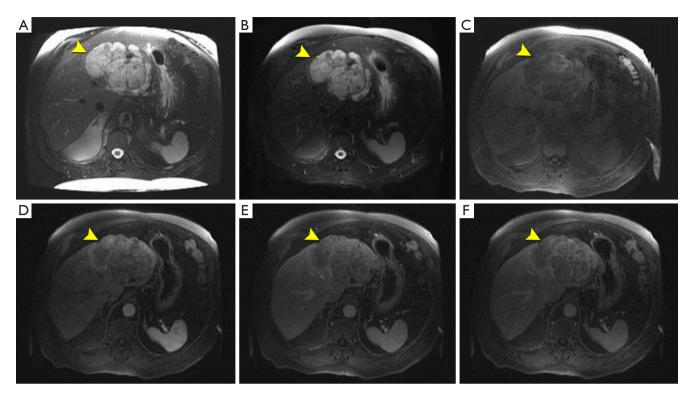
Representative images from the MRI study in Case 1. Axial T2-weighted without fat saturation (A), axial T2-weighted with fat saturation (B), pre-contrast T1-weighted (C) and post-contrast arterial, venous and delayed phase T1-weighted (D-F, respectively) images. Note the mass has a lobulated and septated appearance (yellow arrowheads) with (A,B) heterogeneously increased T2 signal, (C) T1 isointensity to hypointensity, (D) heterogeneous arterial phase enhancement with (E) washout during venous phase and (F) retention of contrast in some regions in delayed phase, likely representing fibrotic regions.
